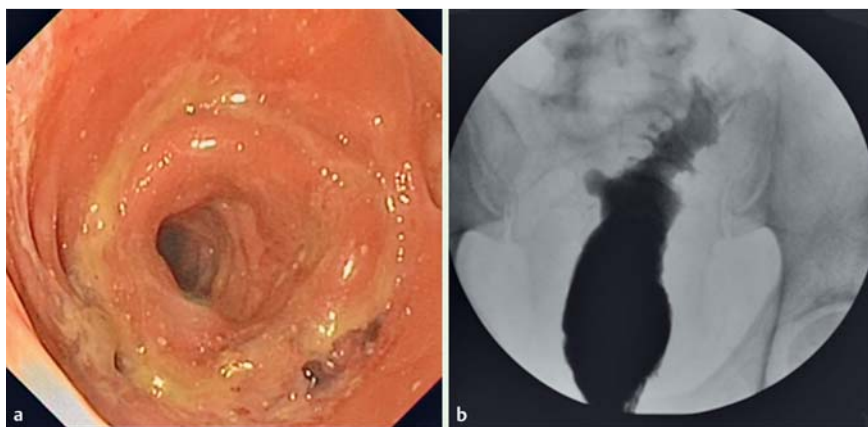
The sealed anastomosis: a endoluminal view; b X-ray view.
